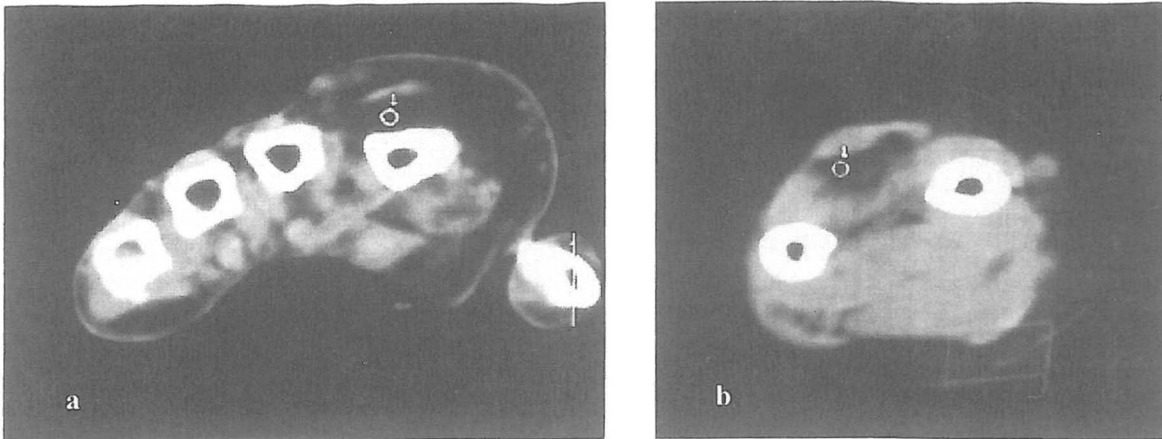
CT scan of the fingers (a) and forearm (b) shows asymmetric fat accumulation (-99Hu).
